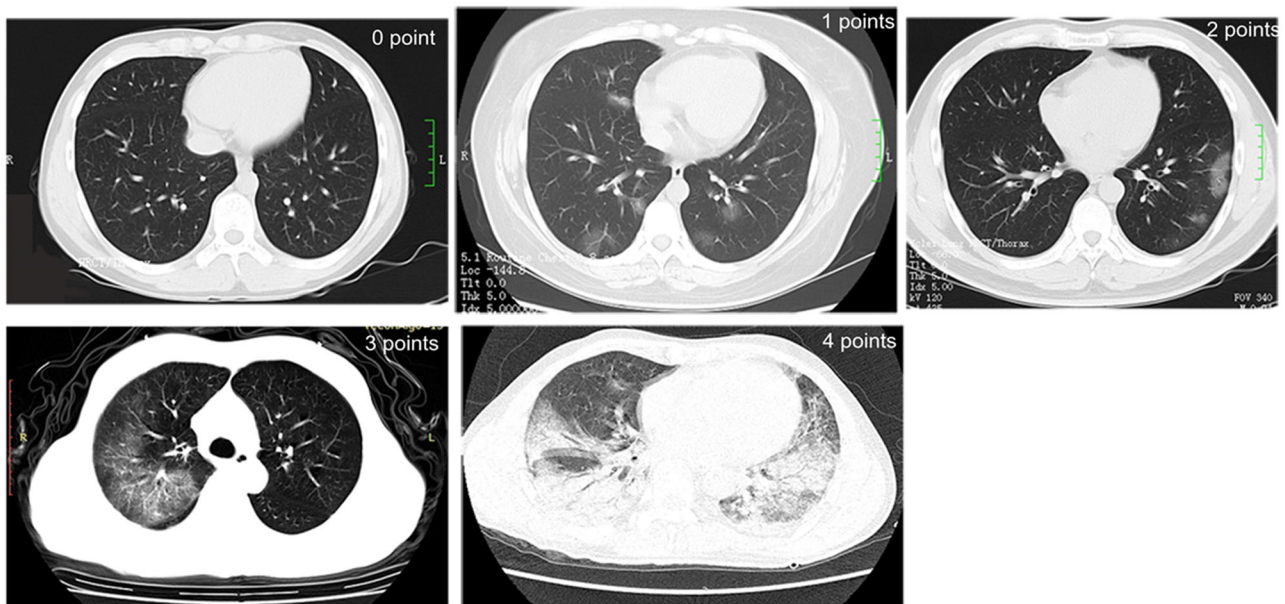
CT Score example: 0 point, Five lobes of lungs are not involved, 0 point for every lobe; 1 point, Minimal involvement (<25%) in right middle lobe, right lower lobe, left upper lobe and left lower lobe, 1 point for each lung lobe, 4 points in total; 2 points, Mild involvement (26-50%) in the left lower lobe, 2 points in the left lower lobe; 3 points, Moderate involvement (51-75%) in the right upper lobe, and 3 points in the right upper lobe; 4 points, Severe involvement (>75%) in right lower lobe, left upper lobe and left lower lobe, 4 points for each lung lobe, 12 points in total
